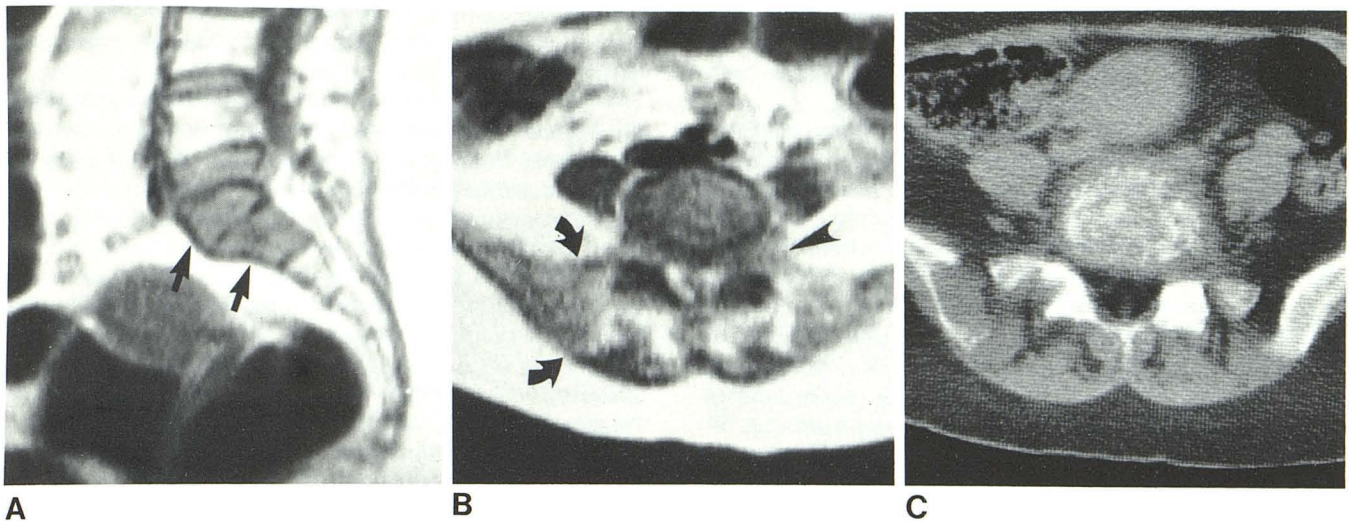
Metastasis from bronchogenic carcinoma. A, SR image. Abnormal, low signal intensities of marrow cavities of S1 and S2 (arrows). Plain radiographs on same day did not reveal abnormality in area. B, Axial NMR image at L5–S1 level. Large area of abnormal signal intensity in ilium at
